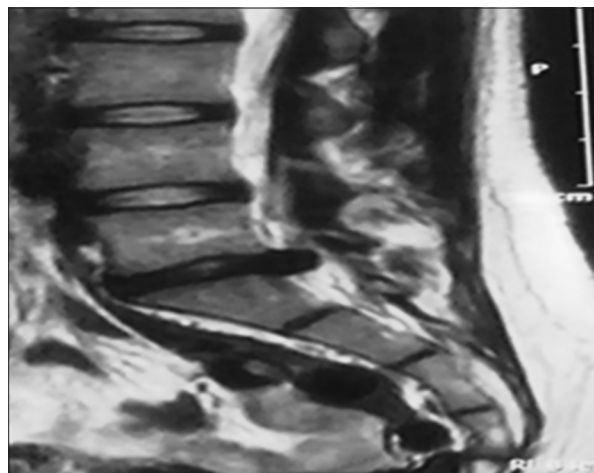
Pre-operative magnetic resonance imaging lumbosacral spine (sagittal T2W images of 19-years-old adolescent with L5-S1 disc herniation)
